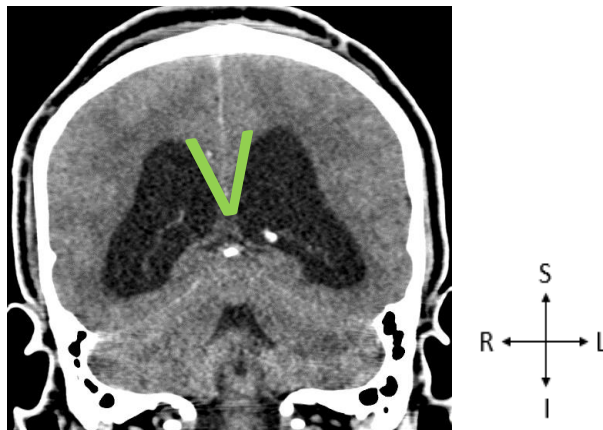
A CT scan of the brain in the coronal view indicating the callosal angle (green). Image taken from the GSH PACS (20 October 2023). S - Superior, R - Right, I - Inferior, L - Left.
